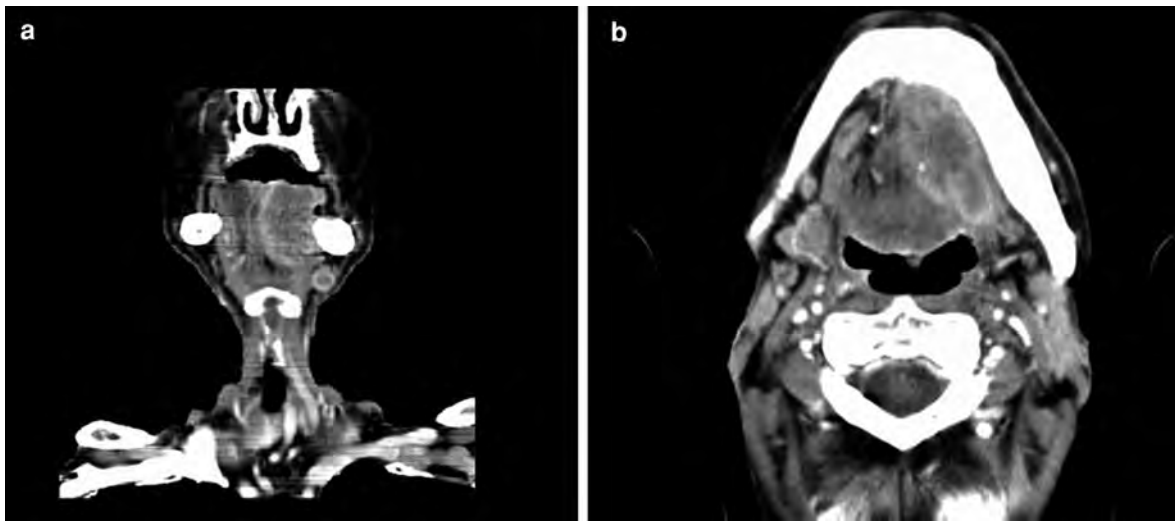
CT with coronal (a) and axial (b) reconstructions of a 60-year-old male with a huge squamous cell carcinoma of the tongue. The tumor extends into the floor of the mouth and reaches the mandible as well as the midline but without
